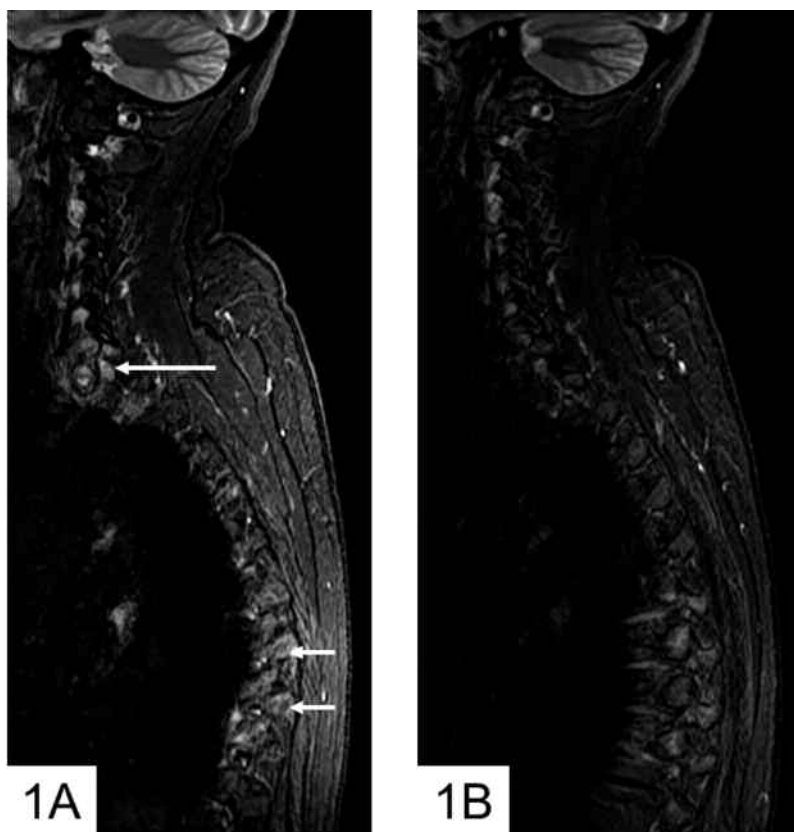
A. Sagittal short-tau inversion recovery (STIR) magnetic resonance (MR) image of the cervical spine before tocilizumab. Marked inflammatory costovertebral lesions are visible at upper thoracic level (long white arrow) and mid-thoracic level (short white arrows). B. Sagittal STIR MR image of the cervical spine after tocilizumab. Normalization of upper thoracic spine with no visible inflammatory lesion. Some residual changes are visible at mid-thoracic level.
